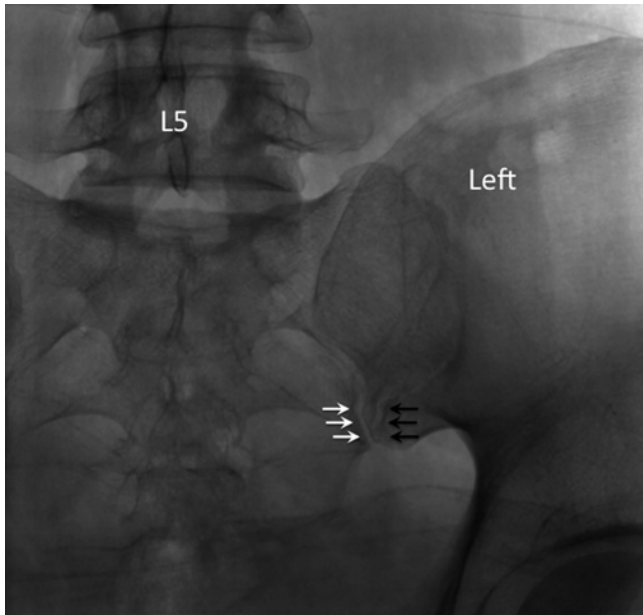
Straight posteroanterior X-ray of the sacroiliac joint. In this view, both anterior (*black arrows*) and posterior joint (*white arrows*) lines are seen. The posterior joint line (*white arrows*) is usually the more medial one (Reproduced with permission of Philip Peng Educational Series)
